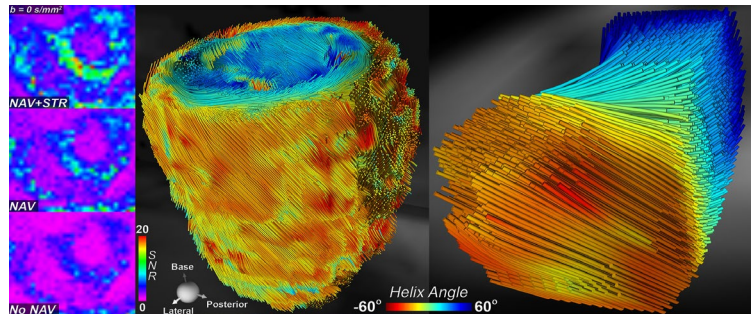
High-resolution DTI tractography of the whole human heart using generalized slice dithered enhanced resolution (gSlider) MRI. Left: Short axis slice showing SNR improvement with slice-following navigation and our spatiotemporal registration algorithm. Center: Fiber tracking of the whole heart of a healthy subject acquired with navigated M2-gSlider. Helix angle is defined with respect to the center axis, base to apex. Right: Section of the same heart showing detail of fiber orientation, epicardial to endocardial.
